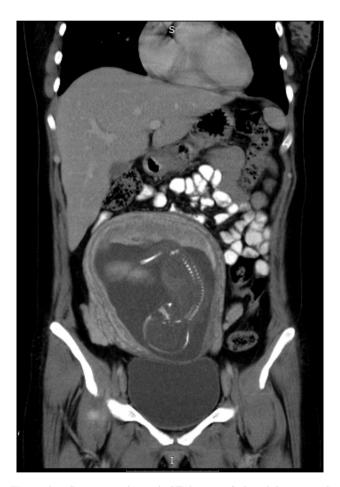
Contrast enhanced CT image of the abdomen and pelvis showing a single intrauterine fetus.
